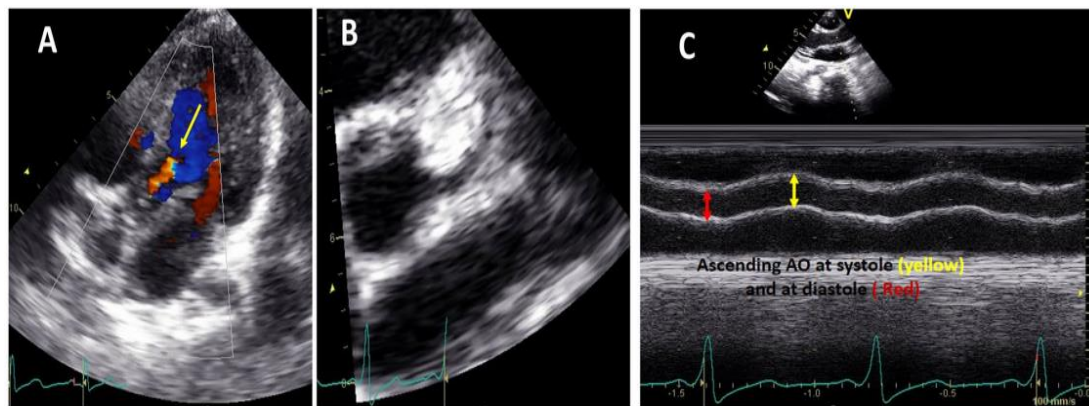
(A) - Color Doppler showing mild aortic insufficiency. (B) - Left coronary artery showing left main coronary artery ectasia. (C) – M-mode measuring systolic (yellow arrows) and diastolic (red arrows) aortic dimensions.
